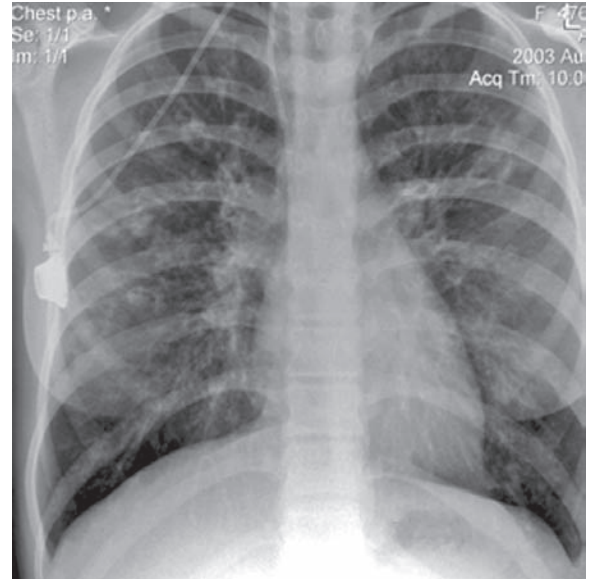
An autosomal recessive error in chloride ion transport results in thick tenacious mucous. Clinical manifestations result from bronchiectasis, lung abscesses, air trapping, airway obstruction and right heart failure. On chest radiograph early CF can be seen as hyperaeration and bronchial wall cuffing. Mucoïd impaction is seen as finger like densities radiating from the hilum. Bronchiectasis is seen as tram tracks radiating from the hilum. Chest radiograph showing lung hyperinflation, patchy infiltrates and peribronchial thickening and dilatation in a 11-year old patient with cystic
